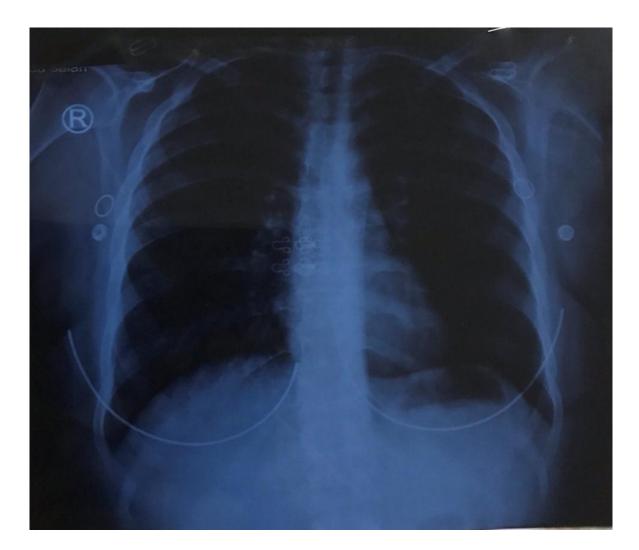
Clear chest X-ray
